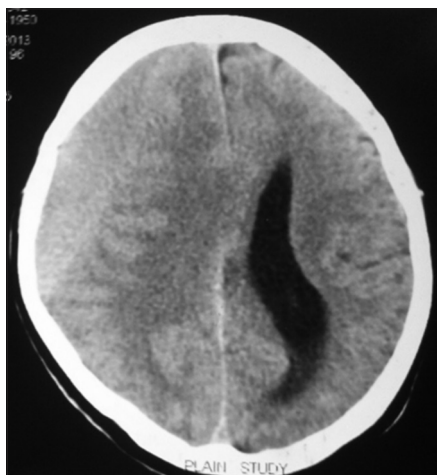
Non-contrast computed tomography of head showing isodense chronic subdural hematoma
